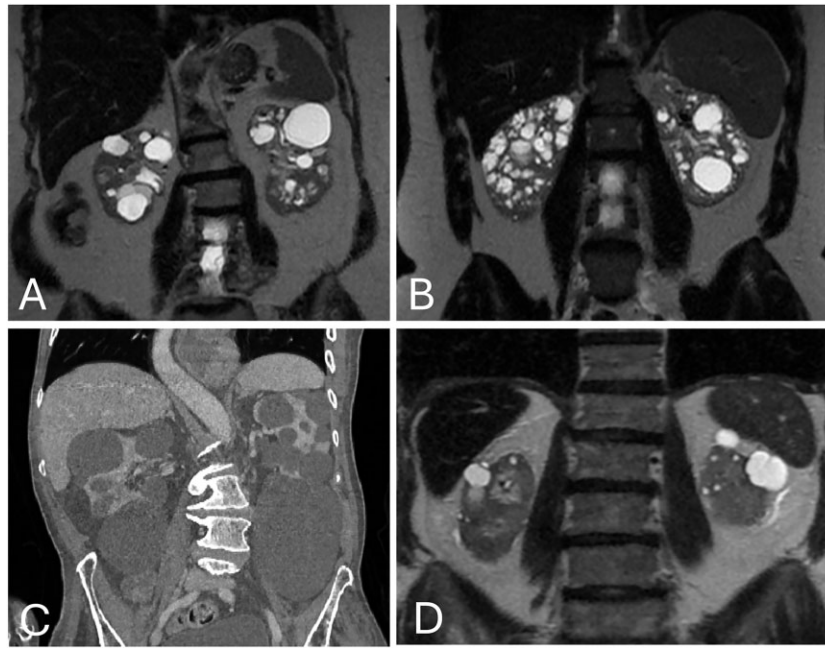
Examples of ADPKD phenocopies. (A) T2-weighted MRI of a 65-year-old woman (eGFR 45 mL/min/1.73 m²) with a large *HNF1B* deletion. (B) T2-weighted MRI of a 37-year-old woman (eGFR 69 mL/min/1.73 m²) with a frameshift variant in *OFD1* (c.710dup). (C) Contrast-enhanced computed tomography of a 68-year-old man (eGFR 56 mL/min/1.73 m²) with a frameshift variant in *COL4A1* (c.1462del). (D) T2-weighted MRI of a 78-year-old man (eGFR 10 mL/min/1.73 m²) with a missense variant in *UMOD* (c.184A>C; p.Thr62Pro).
